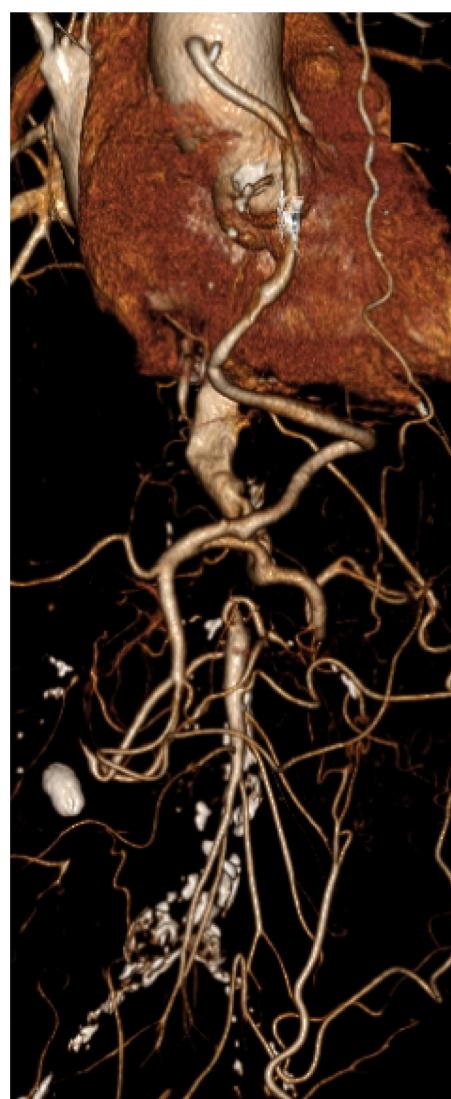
Postoperative 3D CT angiography at 20 months shows a patent aorto-CHA bypass.
